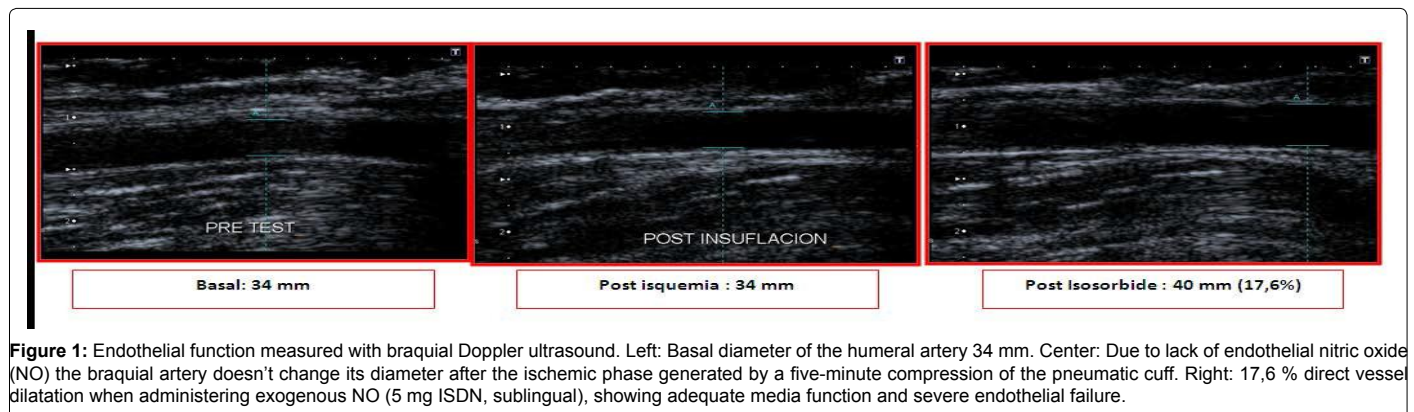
Endothelial function measured with braquial Doppler ultrasound. Left: Basal diameter of the humeral artery 34 mm. Center: Due to lack of endothelial nitric oxide (NO) the braquial artery doesn't change its diameter after the ischemic phase generated by a five-minute compression of the pneumatic cuff. Right: 17,6 % direct vessel dilatation when administering exogenous NO (5 mg ISDN, sublingual), showing adequate media function and severe endothelial failure.
